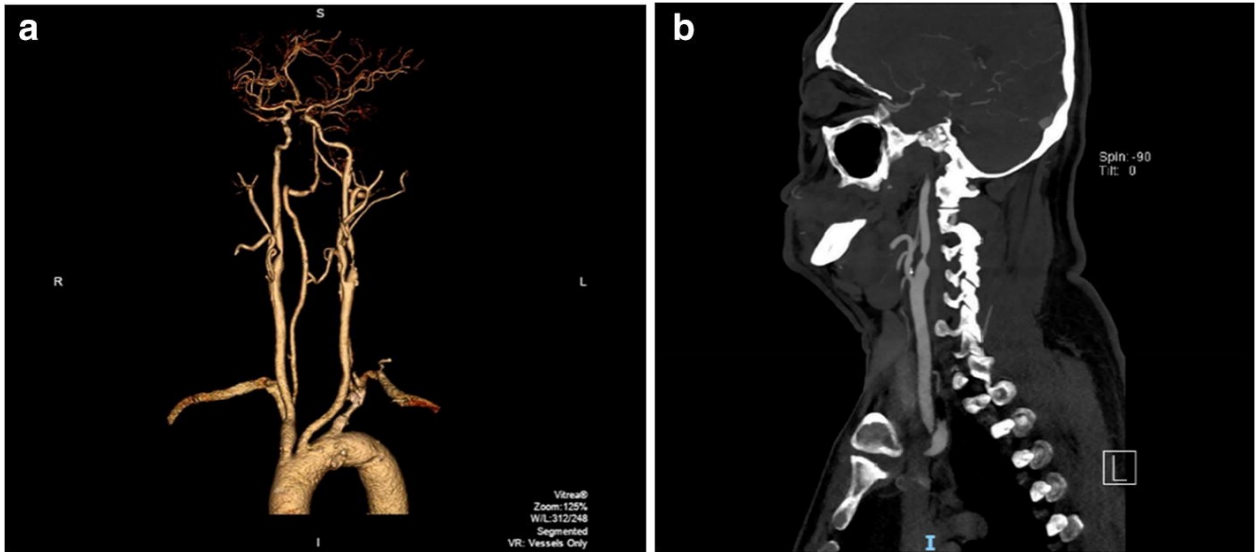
Carotid artery CTA with a 3D reconstruction (a) and a 2D slice image (b) (166). Note: This figure is part of an open-access article from PMC and is in the public domain, allowing its use and reproduction without requesting special permission.
